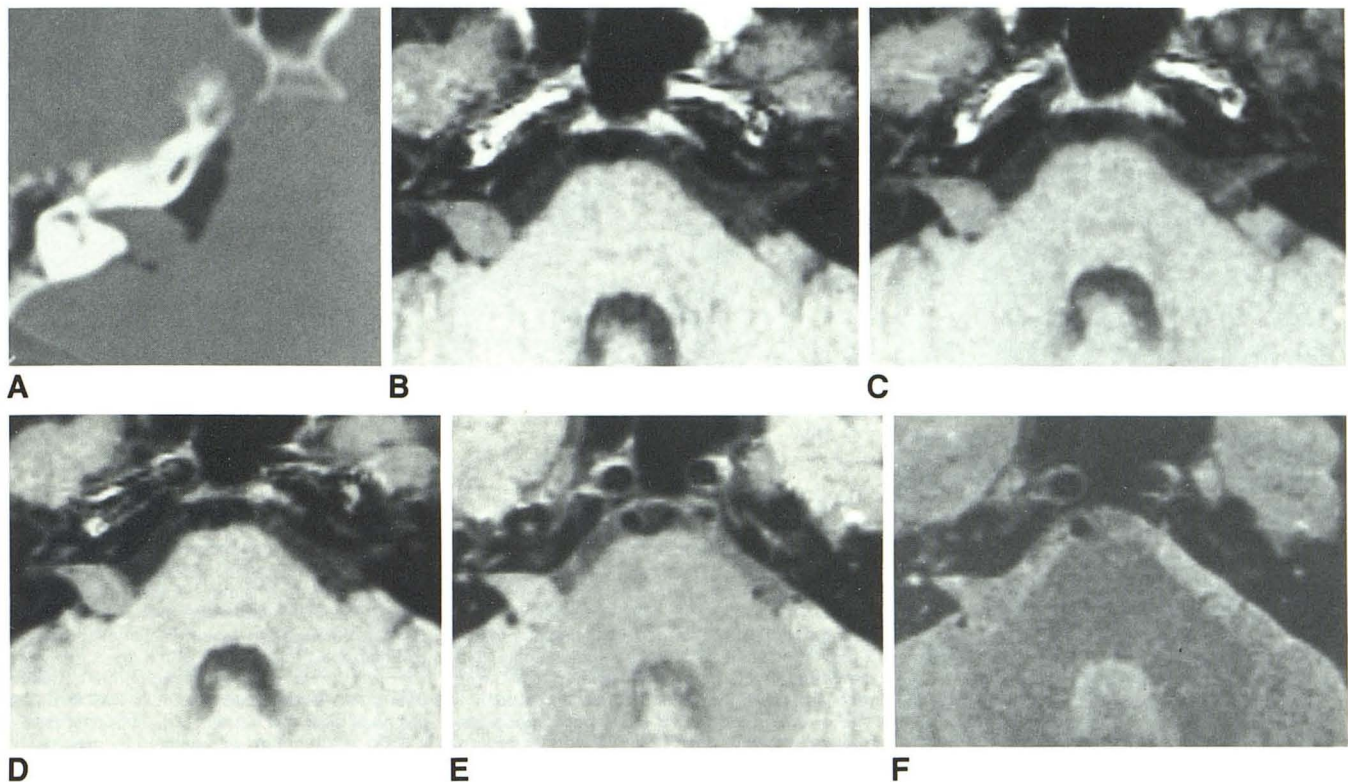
Scans of acoustic neuroma in 38-year-old man with neurofibromatosis show effect of varying TR on the detectability of  $1 \times 1.5$  cm tumor. MR-scan findings correlated closely with appearance of tumor on CT-air cisternogram (A). Short TR sequences were performed as follows: B, TR = 400 msec, C, 600 msec, and D, 800 msec; slice thickness = 3 mm, field of view = 24 cm; matrix  $256 \times 256$  (pixel size = 0.93 mm); and six excitations. Although tumor was seen well in all sequences, highest resolving power was calculated for TR = 800 msec scan (D). Long TR
